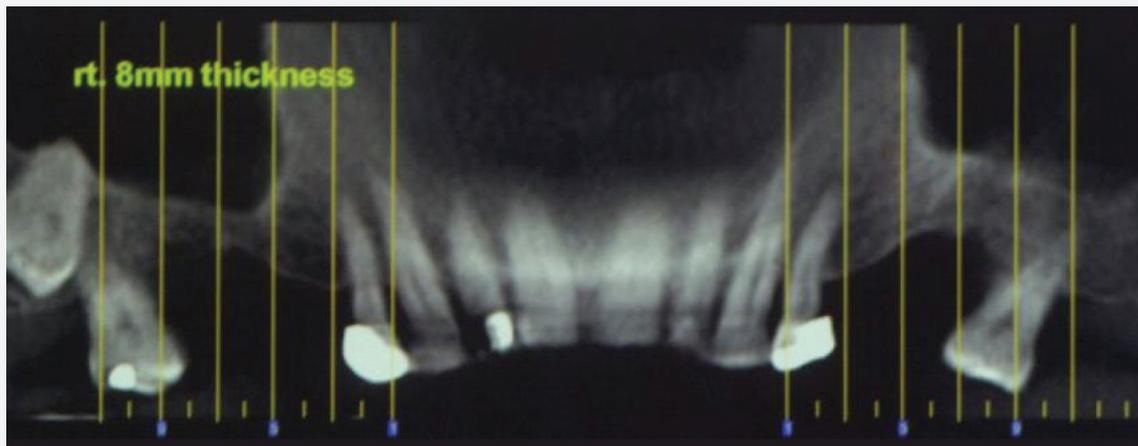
MD- Initial radiographic presentation showing the enlarged sinus cavity.
